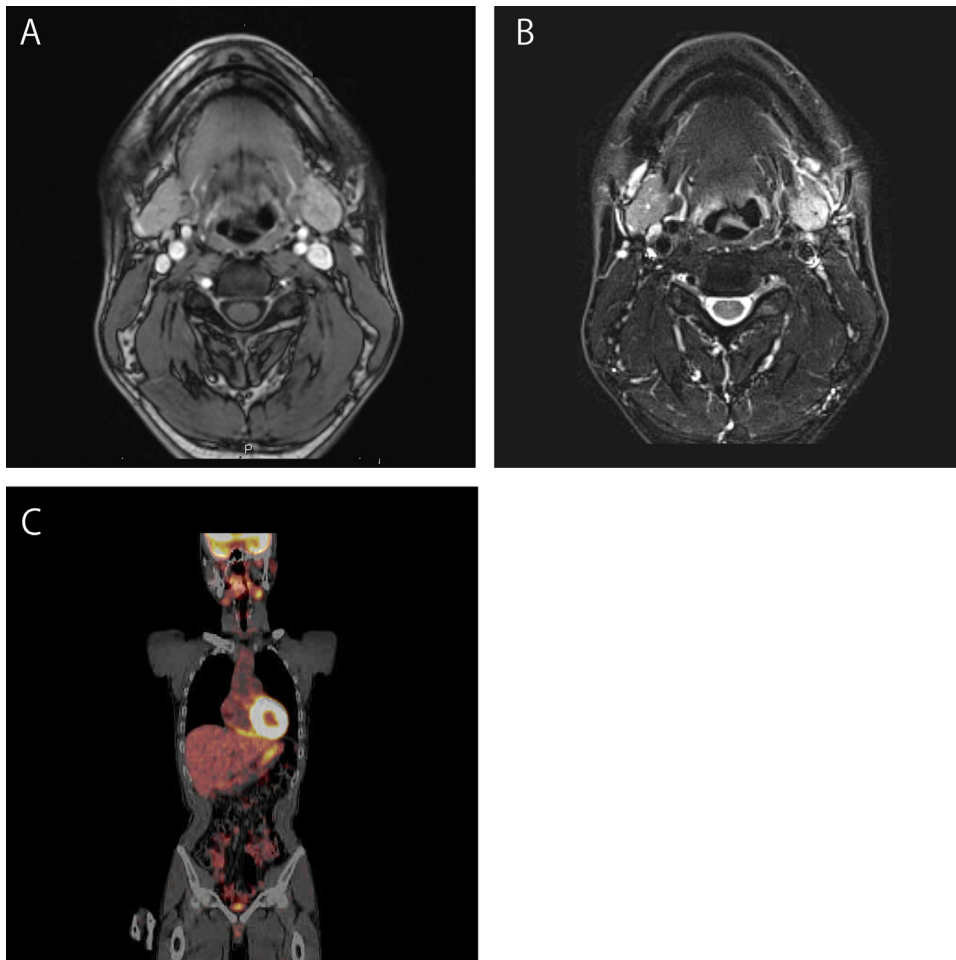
The tumor in the left submandibular gland was hypointense on T1-weighted images (A) and hyperintense on T2-weighted images (B). Its margin was blurred. PET (C) showed abnormal accumulation in the left submandibular gland and gastric wall.
